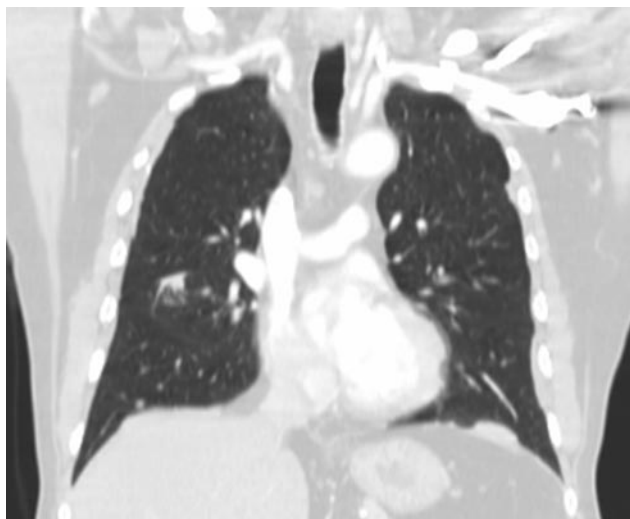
This 3-dimensional computed tomogram reconstruction shows a centrally located, right-middle-lobe, spiculated mass.
